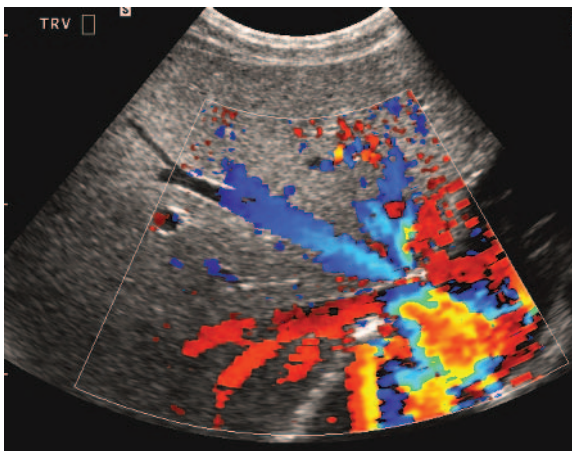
Colour Doppler of the hepatic vein confluence. The right hepatic vein appears red, as it is flowing towards the transducer. The left and middle hepatic veins are in blue, flowing away from the transducer. Note the peripheral middle hepatic vein, which appears to have no flow; this is an artifact due to the angle of that part of the vessel to the beam.
